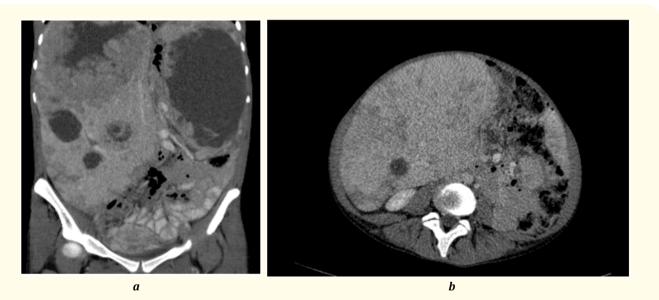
CT Scan before the pregnancy under Imatinib Mesylate.
